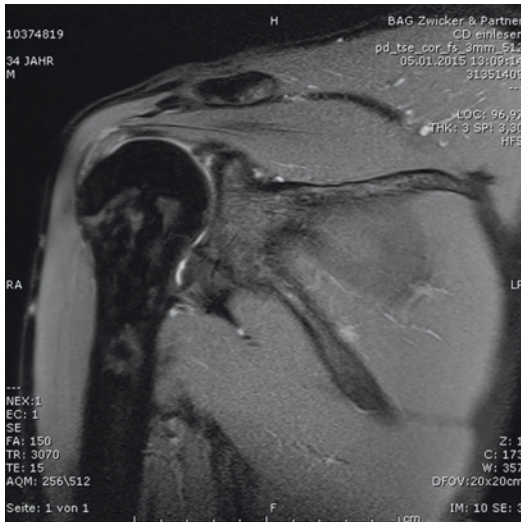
MRI of a shoulder with a SLAP II lesion (Snyder classification)
